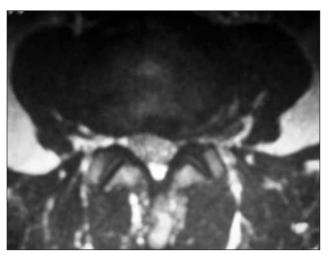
Preoperative axial magnetic resonance image.
